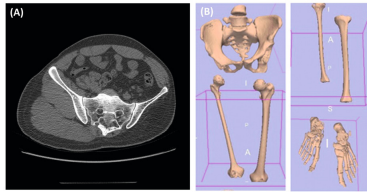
(A) Raw CT image and (B) 3D reconstruction of bone tissues of the lower limbs structures
